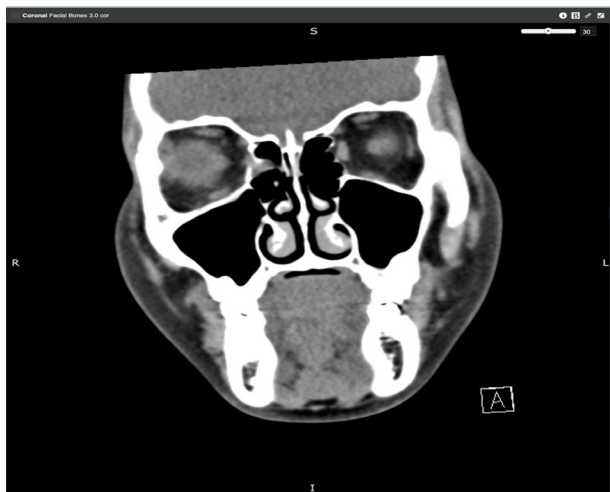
Coronal View of maxillofacial CT scan. CT scan shows medial wall fracture with medial rectus entrapment.
